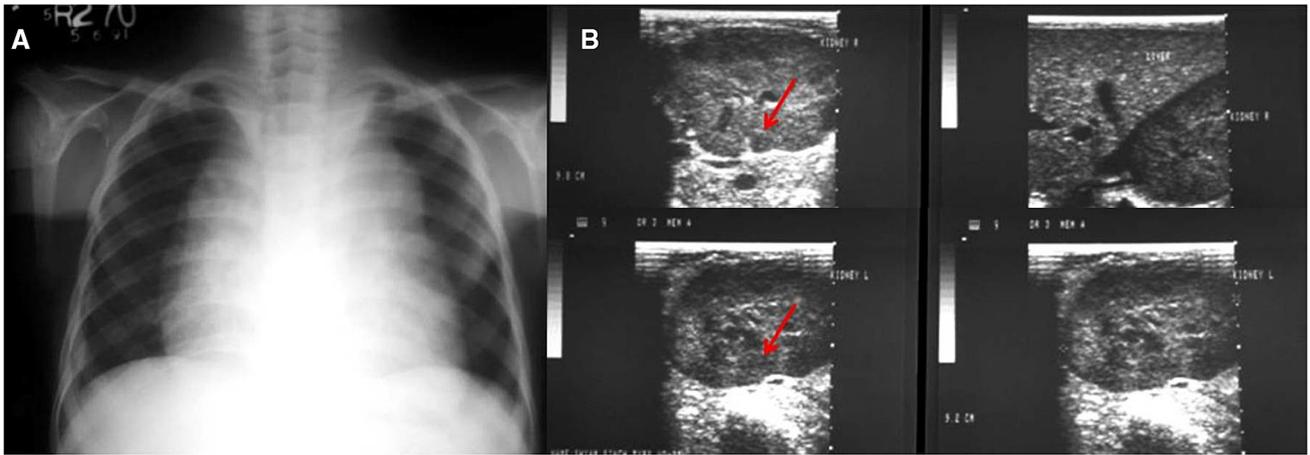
A, B Chest radiograph (A) and the ultrasound examination of the abdomen (B) in a boy of 5 years who is a known case of lymphoma, shows mediastinal lymphadenopathy (A) and that both kidneys are enlarged
